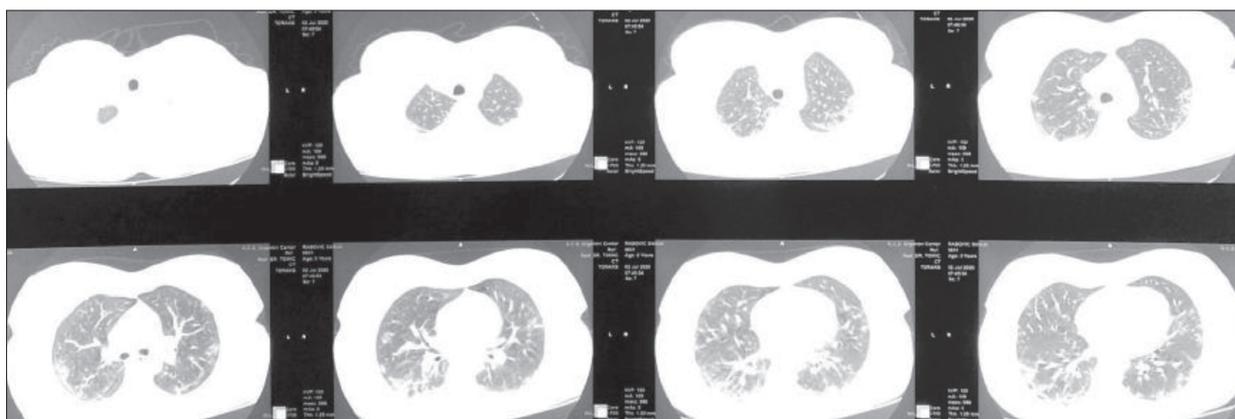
First computed tomography scan showing multiple subpleural ground glass opacifications
